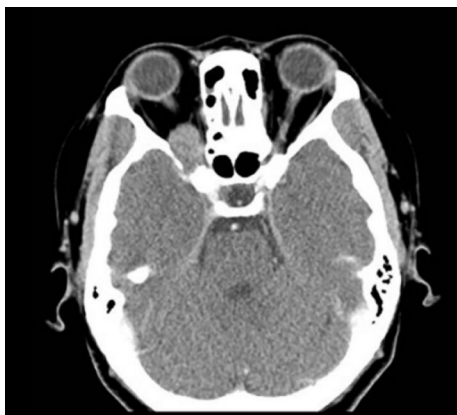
CT image demonstrating a well-circumscribed intraconal tumor about 19 × 15 –mm² in size abutting the superior and lateral aspect of the apical optic nerve. The lesion extends through an expanded sphenoidal fissure to the middle cranial fossa.
